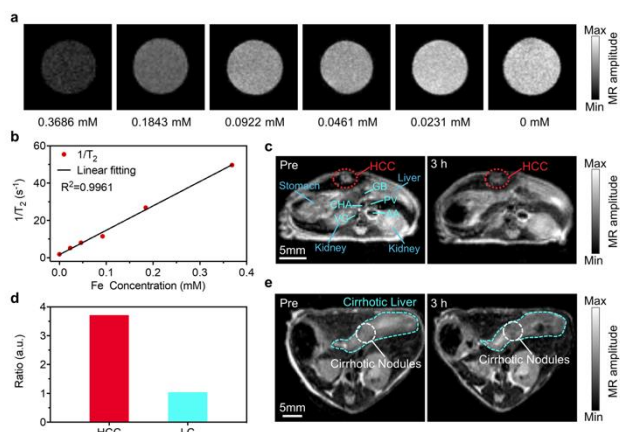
In vivo* MRI for high spatial-resolution diagnosis of early HCC at the PAI-guided optimal imaging time. (a) T₂-weighted MR images of different concentrations of Fe (mM). (b) Relaxation rates $1/T_2$ (s⁻¹) of targeted nanoprobe as a function of Fe concentrations (mM). (c) T₂-weighted MR images of orthotopic HCC pre- and 3 h post- injection of targeted nanoprobe intravenously (250 µg mL⁻¹, 2.5 mg kg⁻¹) in grayscale. The HCC tumor is circled with red dotted lines. GB: Gall bladder, CHA: Common hepatic artery, PV: Portal vein, AA: Abdominal aorta, VC: Vena cava. (d) The ratio of T₂-MR signal pre/3h in the HCC and LC. (e) T₂-weighted MR images of LC pre- and 3 h post- injection of targeted nanoprobe intravenously (250 µg mL⁻¹, 2.5 mg kg⁻¹) in grayscale. The liver region is circled with the blue dotted lines. The typical cirrhotic nodules were circled with white dotted lines. Scale bar: 5 mm.
